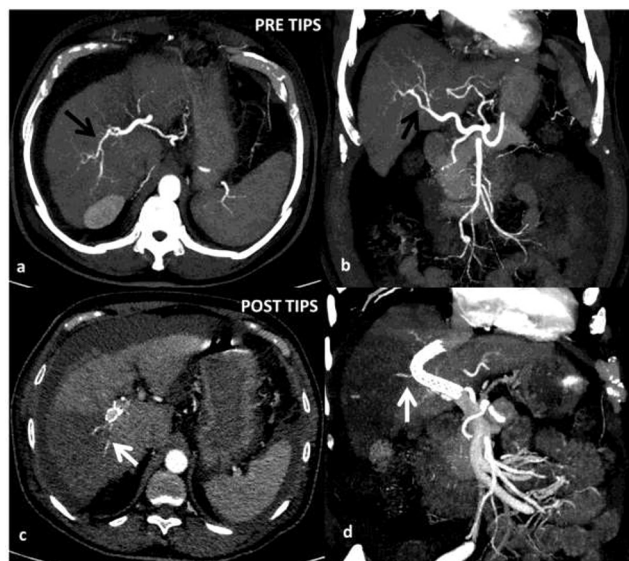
A 73-year-old man, known case of cirrhosis, presented with refractory ascites. Pre- and post-TIPS comparison of CECT scan arterial phase, axial and coronal images. (a, b) Pre-TIPS. MIP images showing normal anterior and posterior sectoral branches of RHA. (c, d) Post-TIPS. CT scan images showing attenuated posterior sectoral branches of RHA.
